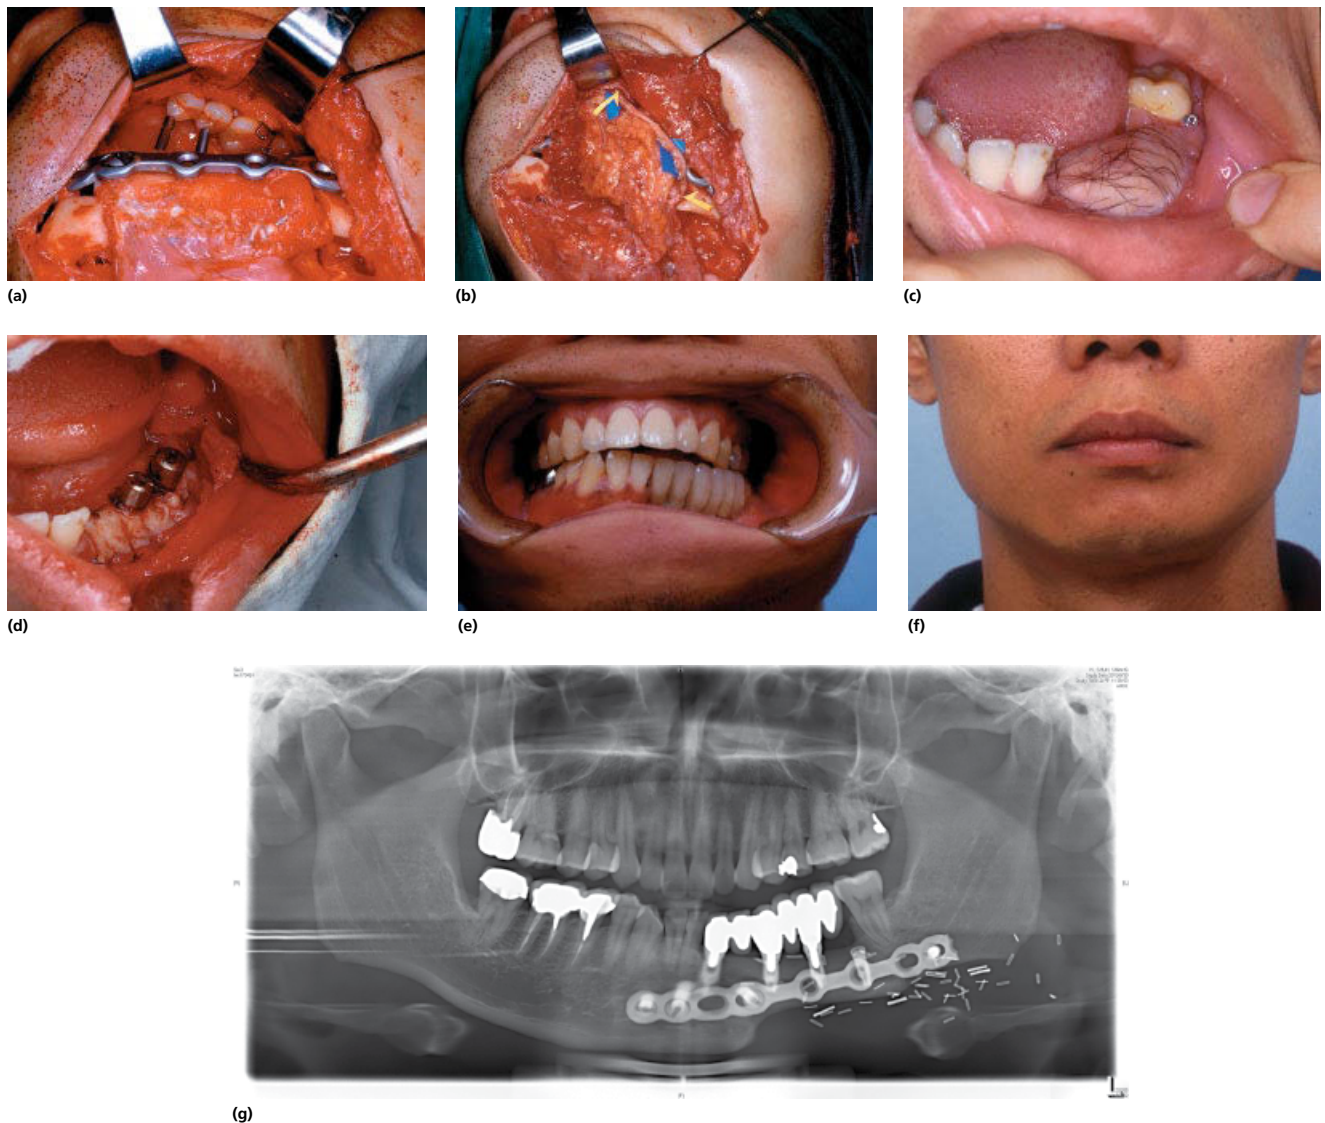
Recurrent ameloblastoma of the mandible segmentally resected and reconstructed with a fibula osteoseptocutaneous flap with simultaneous osseointegrated dental implantation for dental rehabilitation and sural nerve graft for restoration of lip and chin sensation. (a) Resultant mandibular defect reconstructed with a fibula osteoseptocutaneous flap and simultaneous osseointegrated dental implantation. Proper occlusion confirmed with guiding screws. (b) Mental nerve defect reconstructed with a sural nerve graft. (c) Appearance after initial reconstruction. (d) Palatal mucosa graft to replace the skin island around the abutments. (e, f) External and occlusal appearance 3 years after surgery. (g) Panorex radiograph 15 years after surgery.
